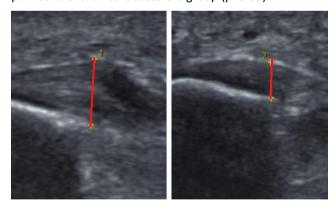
Estimation of Plantar Fascia Thickness by Ultrasonography
